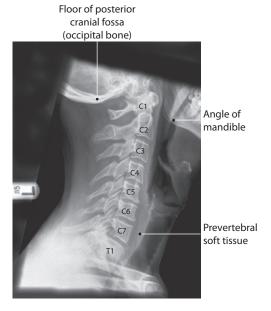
Example of a lateral cervical spine radiograph.
